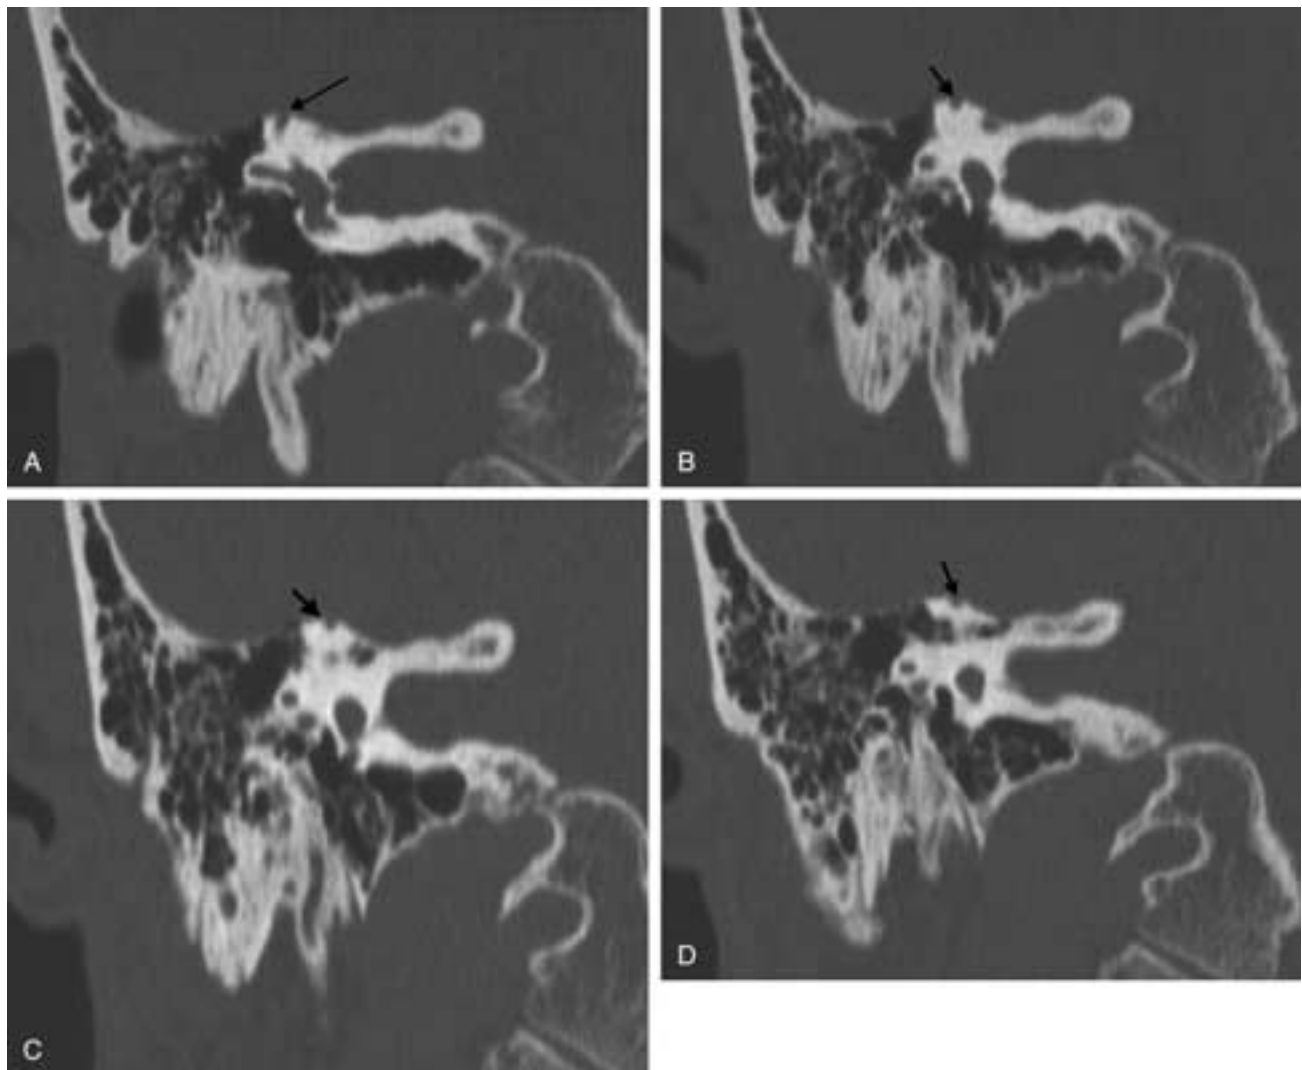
Tullio’s phenomenon: pressure- or sound-induced vertigo. A to D, four contiguous coronal CT images showing dehiscence of the right superior semicircular canal (black arrows).
